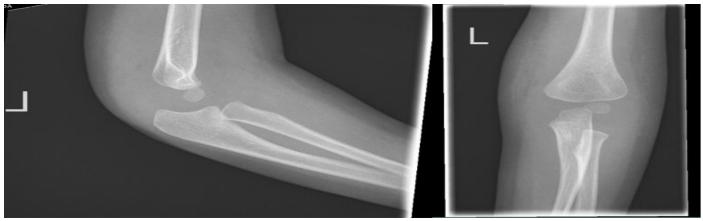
Xray AP,Lat at Initial Presentation
